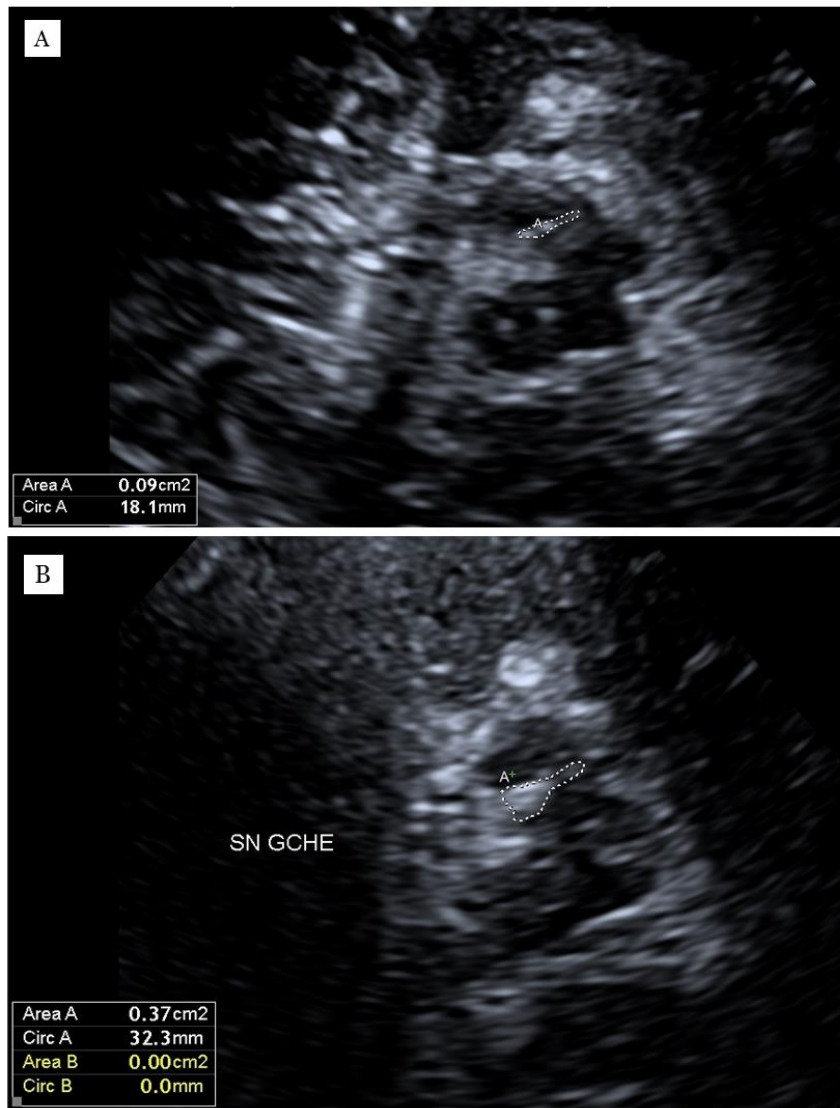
Transcranial sonography of the midbrain. Picture A: Midbrain (visible as a butterfly-shaped structure) of a healthy control with normal echogenicity of the substantia nigra (delineated ipsilaterally with a dotted line). Picture B: In a patient with Parkinson's disease, the area of hyperechogenicity at the anatomical site of the SN is enlarged (encircled ipsilaterally with a dotted line). These pictures have been acquired in our movement disorder clinic, with kind contribution of Dr E. Parmentier and Dr E. Drion.
